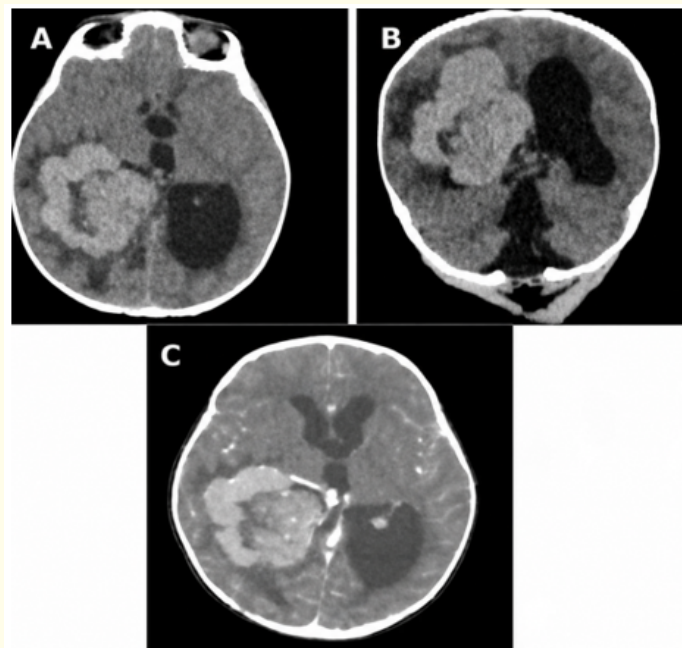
Brain CT. Axial unenhanced (A) and coronal unenhanced (B) images show a large lobulated heterogeneous hyperattenuating mass centered on the right lateral ventricle, with marked asymmetric obstructive hydrocephalus and mass effect. Axial contrast-enhanced CT (C) demonstrates intense heterogeneous enhancement, internal non-enhancing areas, and prominent intratumoral vessels.
